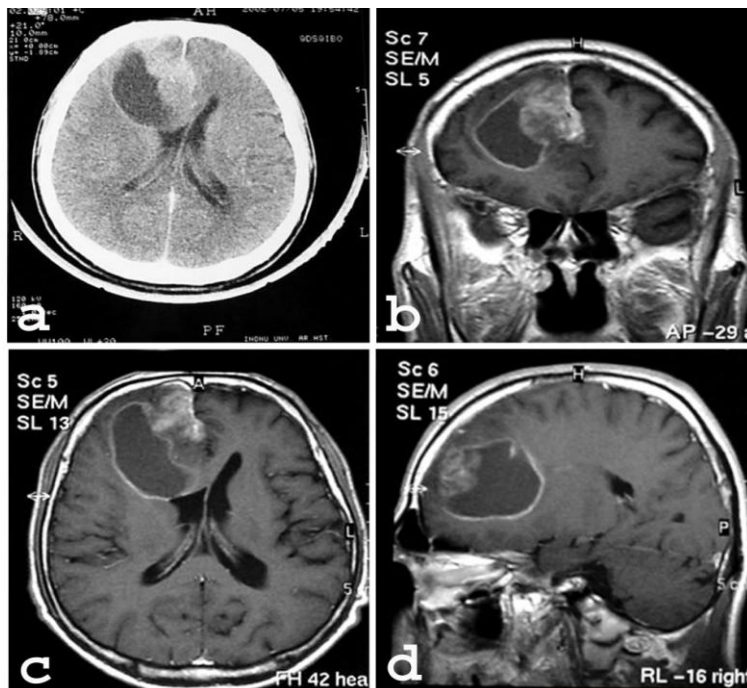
a-Contrasted cranial axial CT showing cystic and solid tumor revealing enhancement in the solid area. b-T1-weighted contrasted coronal MRI showing solid-cystic lesion reaching the interhemispheric fissure in the right frontal region. c-T1-weighted contrasted axial MRI showing the enhanced tumor compressing the right frontal horn. d-T1-weighted contrasted sagittal MRI showing solid-cystic lesion in the frontal area.
